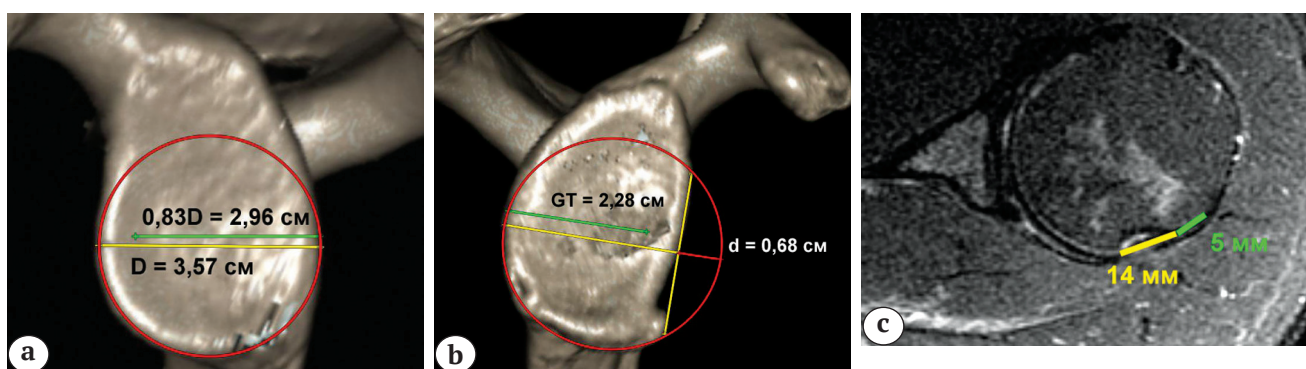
Evaluation of track for articular process of scapula in bipolar injuries of shoulder joint: a — measurement of diameter of intact glenoid ($D = 3.57$ cm); b — calculation of defect width ($d = 0.68$ cm) and glenoid track ($GT = 2.28$ cm); c — MRI measurement of Hill-Sachs interval ($HSI = 1.9$ cm) including the defect itself ($HS = 14$ mm) and bony bridge ($BB = 5$ mm). Based on the fact that glenoid track is wider than Hill-Sachs interval ($GT > HSI$) the bipolar lesion was considered “on-track”
